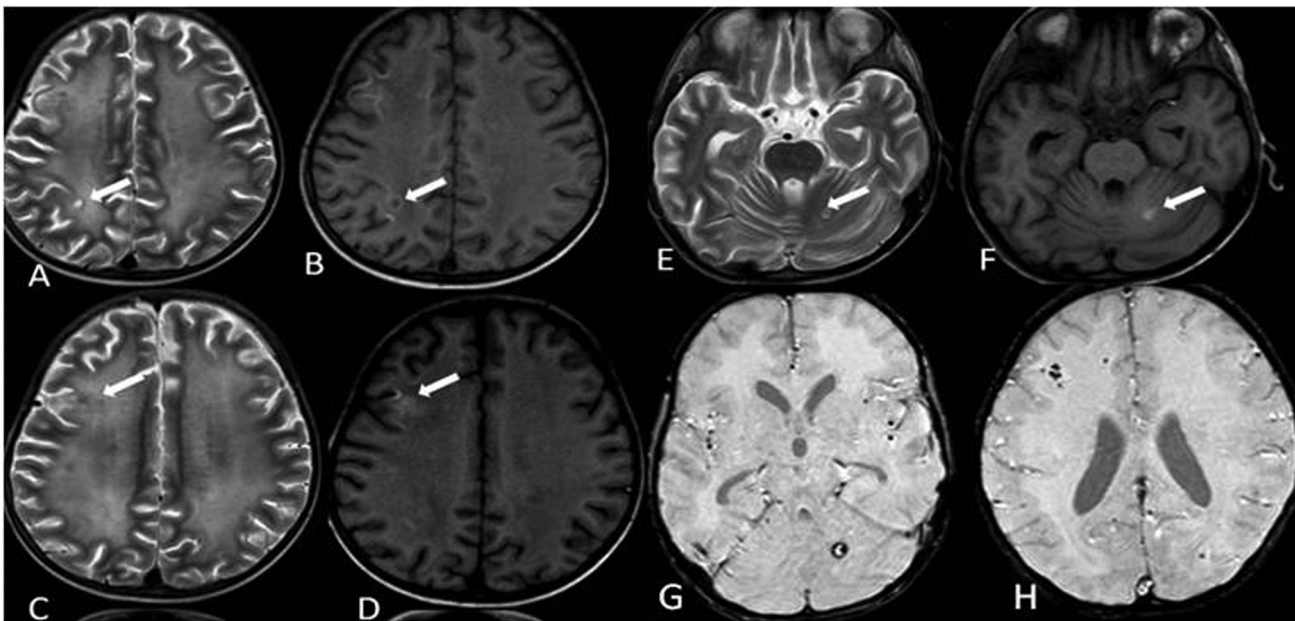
Case 1: (A) Axial T2-weighted (T2W) and (B) axial T1W showing T2 hyperintense lesion with peripheral hypointensity in right posterior centrum semiovale (white arrow). (C) Axial T2W and (D) axial T1W showing T2 hypointense and T1 hyperintense lesion in right middle frontal gyrus (white arrow). (E) Axial T2W and (F) axial T1W showing hyperintense lesion in left cerebellar hemisphere (white arrow). (G) and (H) Axial susceptibility-weighted imaging showing foci of signal loss on gradient imaging within the lesions, suggestive of hemorrhagic residue.
